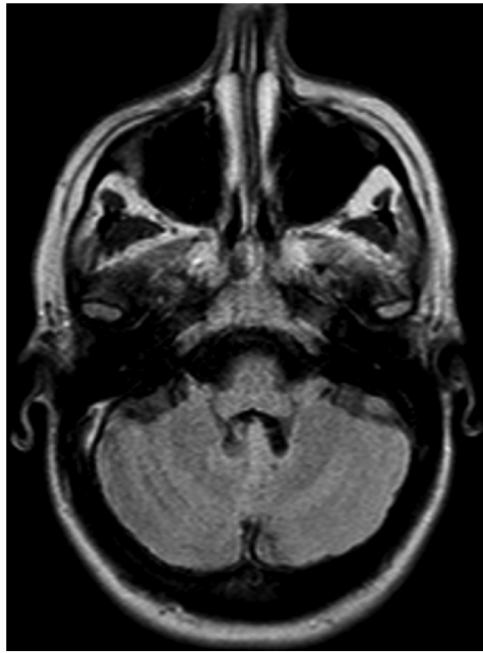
Cerebellar MRI scan.
